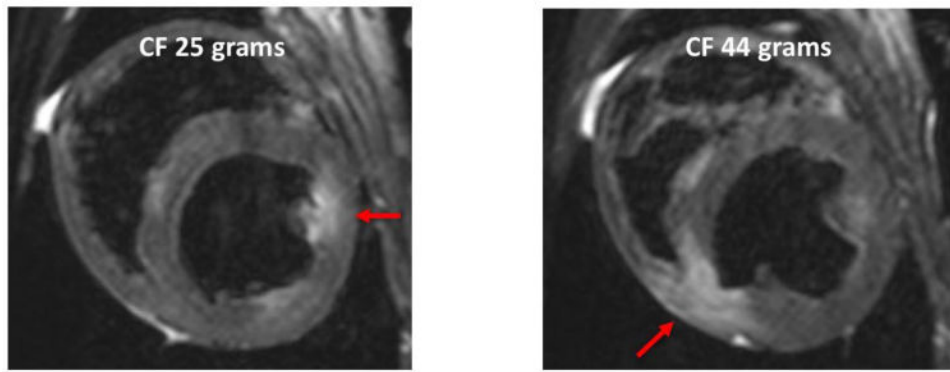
T2 weighted MRI for 25 and 44 gram force. Arrows point to the area of enhancement in the ventricles.
